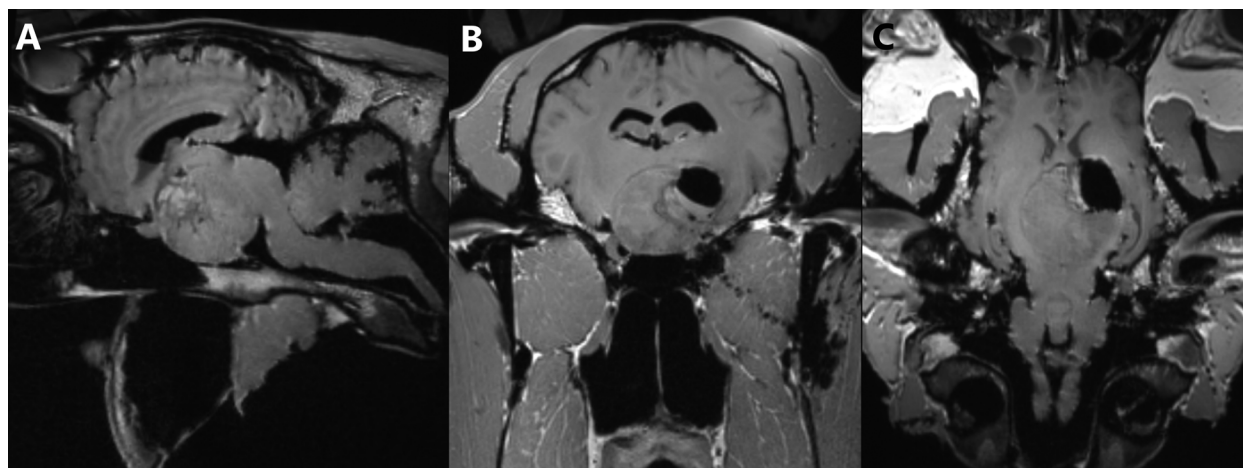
Post-mortem T1w high-resolution 3D reconstructable magnetization-prepared gradient-echo (3D MP-RAGE), (A) transverse, (B) sagittal and (C) dorsal plane magnetic resonance images of the head of a 16-year-old warmblood mare, depicting partial removal of the adenoma, but also inadvertent removal of portions of the thalamus.
